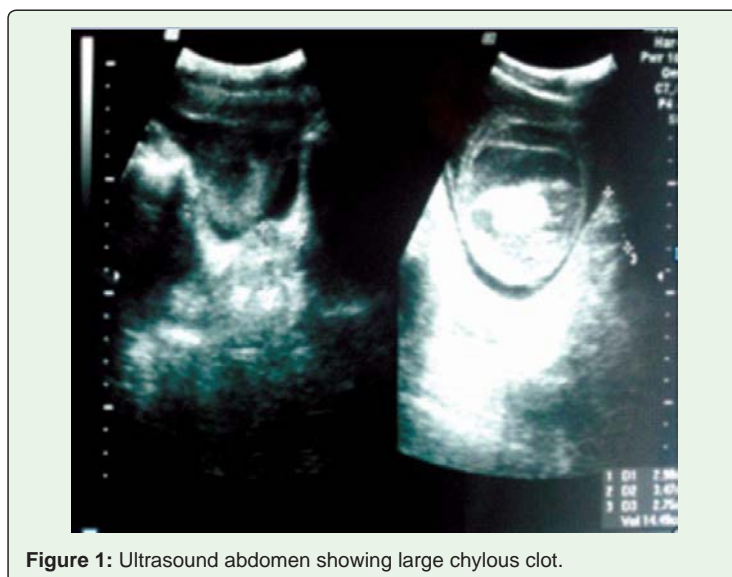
Ultrasound abdomen showing large chylous clot.
